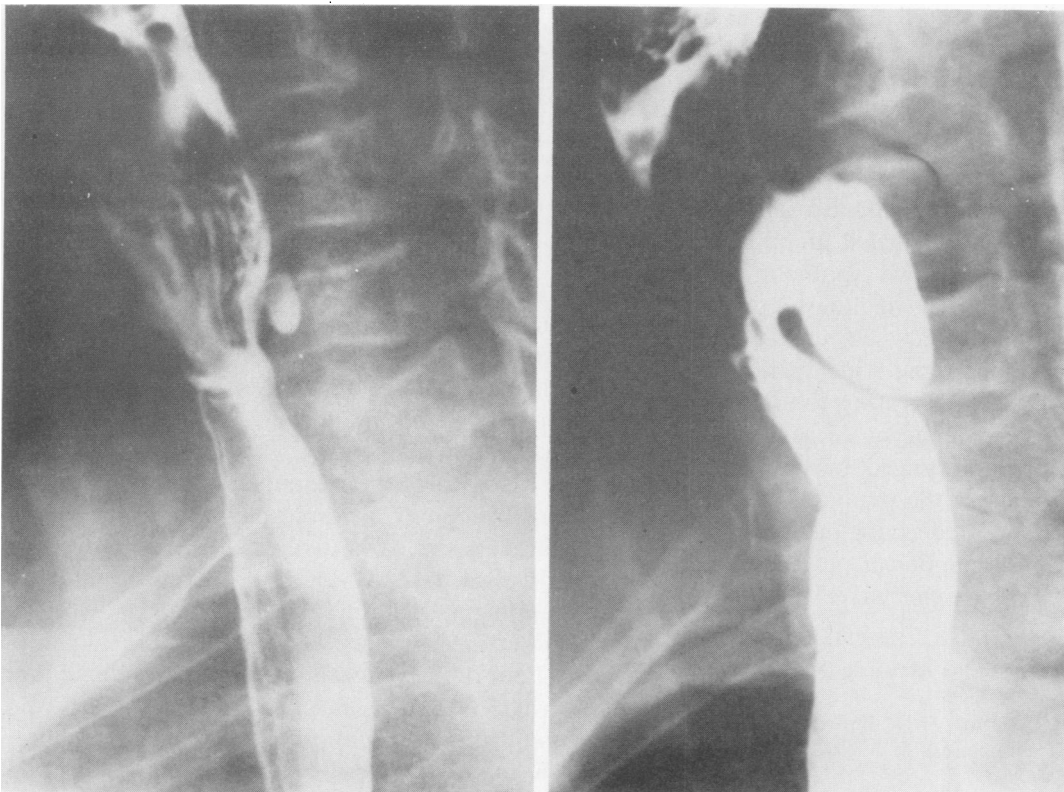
Roentgenographic appearance of developing pharyngoesophageal diverticulum with a three-year interval between the roentgenograms.
